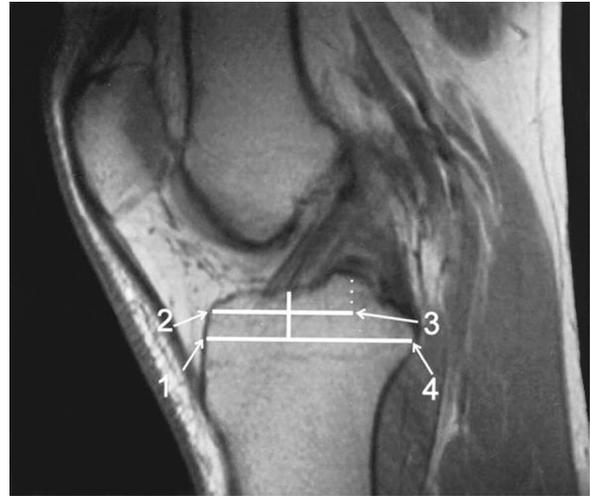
MRI scan showing the center of the ACL and its position relative to two lines on the tibia: (I) the line between the most anterior point on the anterior cortex (1) and the most posterior point on the posterior cortex (4), and (II) the line between the most anterior point on the tibial joint surface (2) and the most posterior point on the tibial surface (3).
